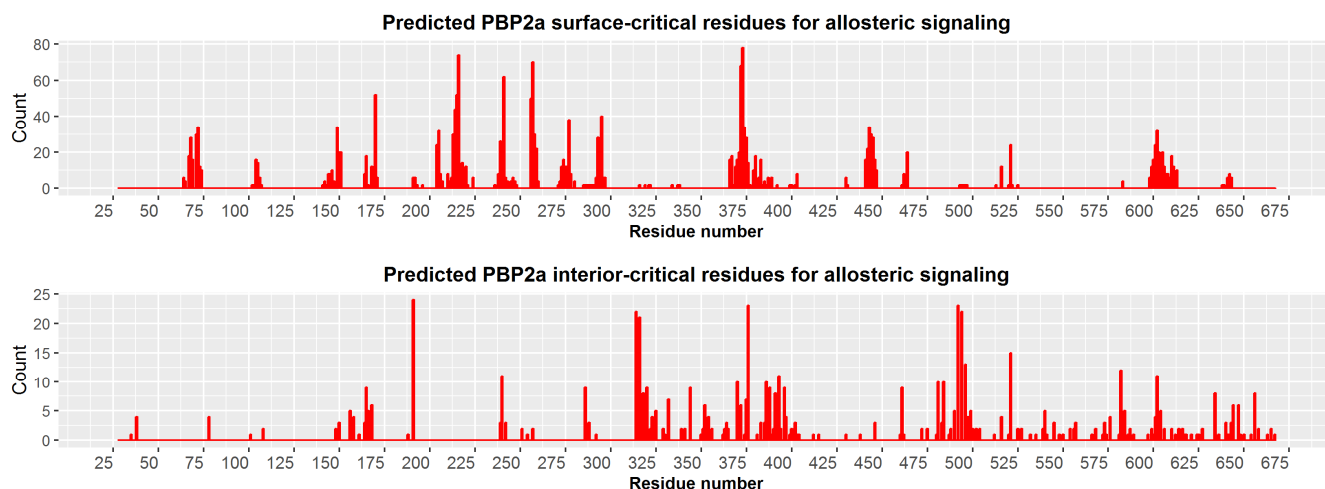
Predicted surface-critical and interior-critical residues from STRESS calculations. X-axis represent frequency of occurrence of the residues from the 24 independent calculations, each from a different X-ray structure monomer chain. Residues of the top-ranked five predicted sites for each X-ray structure were kept for the analysis for surface-critical residues.
